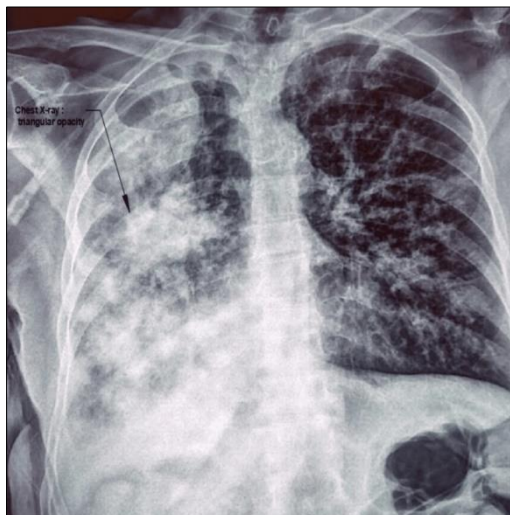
Chest X-ray showing a dense, homogeneous triangular opacity in the right upper lobe with regular contours. Also visible are a second heterogeneous spiculated opacity in the mid-right lung field and confluent nodular and alveolar opacities in the lower third of the right lung, with additional interstitial changes in the left mid-lung zone
